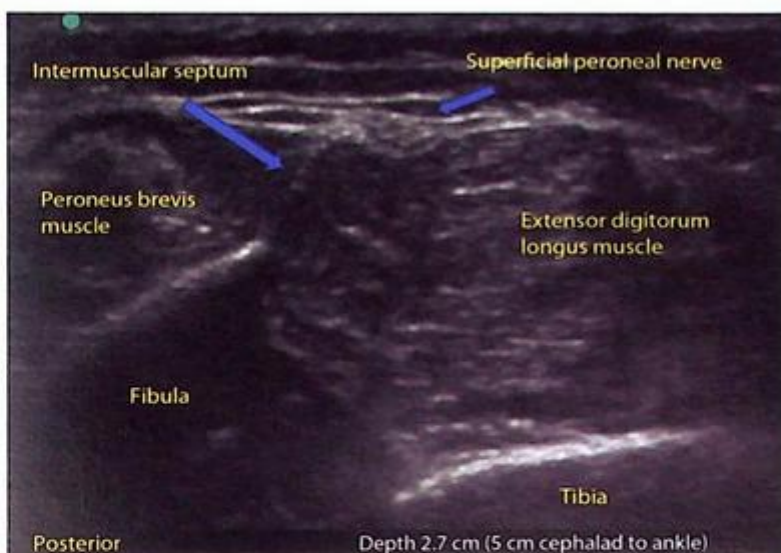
Ultrasound still of the superficial peroneal nerve and surrounding anatomy.
